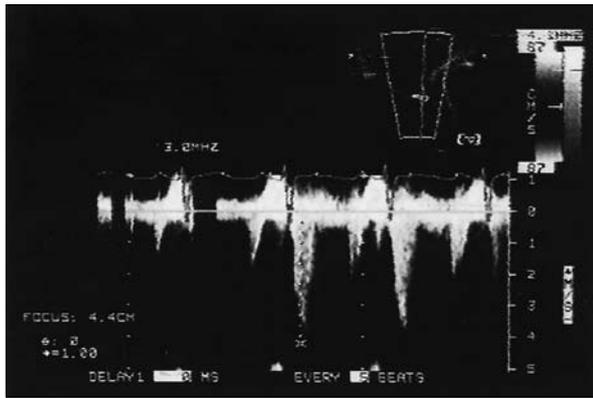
Pre-operative 4 chamber view, using Doppler waves at tricuspid valve regurgitation jet, showing flow of 79 mm Hg.
